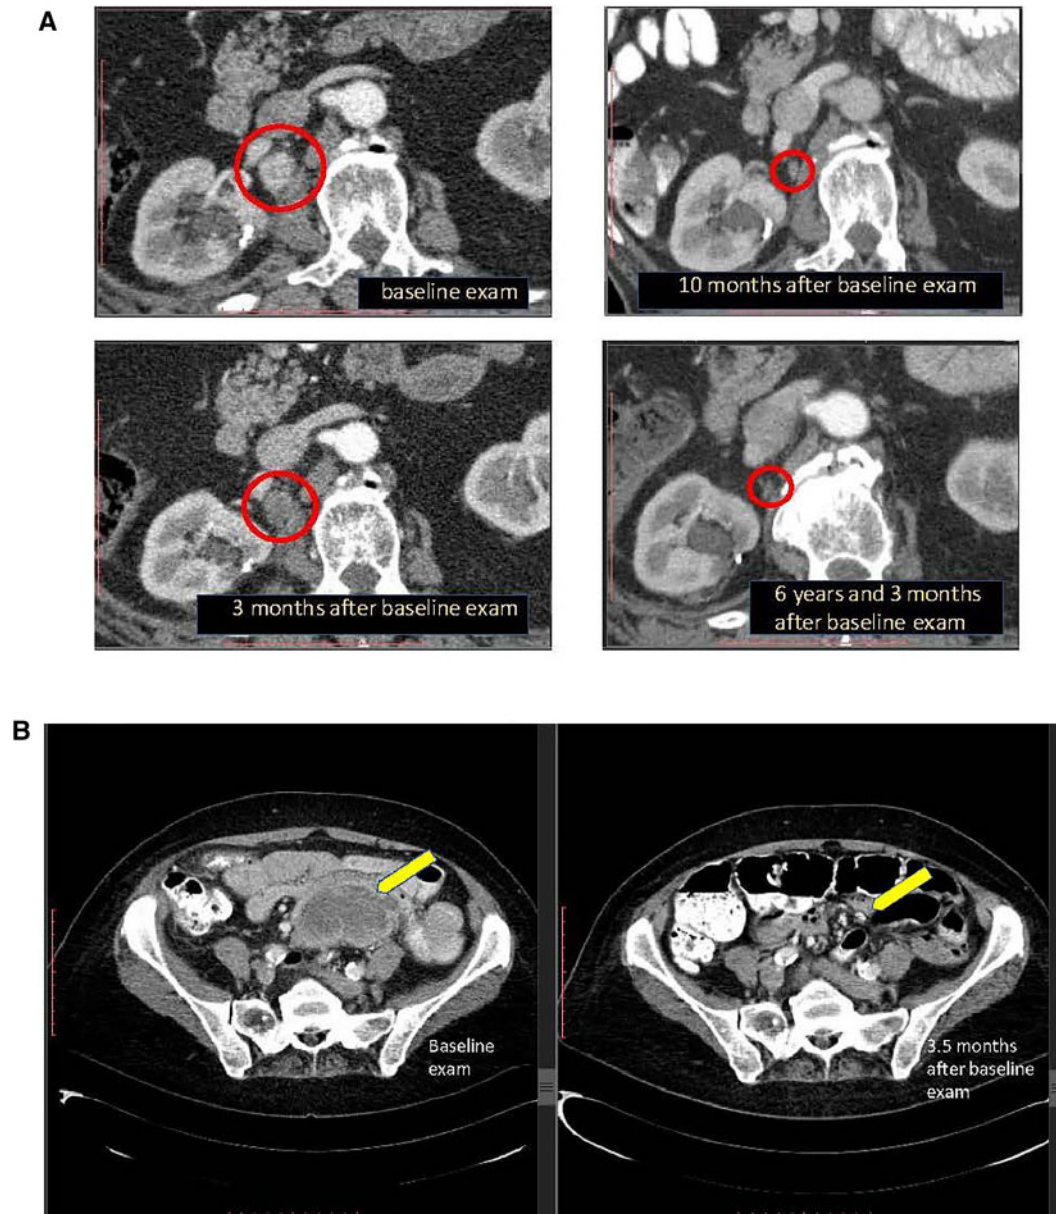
Computerized Axial Tomography (CT) images from 2 cases evaluating exceptional response to therapy. A) Case 94 (Supplementary Table 3, available online) with metastatic clear cell carcinoma of kidney, treated with sunitinib continuously beginning approximately 2 weeks after baseline imaging exam. Contrast enhanced CT scans of the abdomen, soft tissue windows; axial images at the level of the takeoff of the right renal artery. Baseline exam: 1.7×2.1 cm retroperitoneal mass and/or lymph node (mass highlighted in circle) posterior to the mid-right renal artery and immediately lateral to the right iliopsoas muscle. Three months later, the mass highlighted in circle is smaller, 1.3×2.0 cm and does not enhance. Ten months after baseline exam, the same mass is 0.6×1.0 cm. Six years and 3 months after baseline exam, the mass is 0.3×1.2 cm without evidence of additional metastatic disease (residual stable imaging changes considered CR). B) Case 46 (Supplementary Table 3, available online) with metastatic squamous cell lung cancer and biopsy proven metastasis to cecum treated with weekly paclitaxel and carboplatin for 10 months. Baseline imaging also showed metastases in lung, liver, kidney, and mesentery (arrow). Contrast-enhanced CT scans of the abdomen, soft tissue windows; large mid-upper pelvic mass with lower-density center. Baseline exam (image on left): 5.8×8.4 cm with lower density in the center of the mass (arrow). CT scan 3.5 months later (image on right): This partially necrotic mass was not seen. Repeat CT of chest, abdomen and pelvis more than 3 years after the 3.5-month scan demonstrated no evidence of disease.
